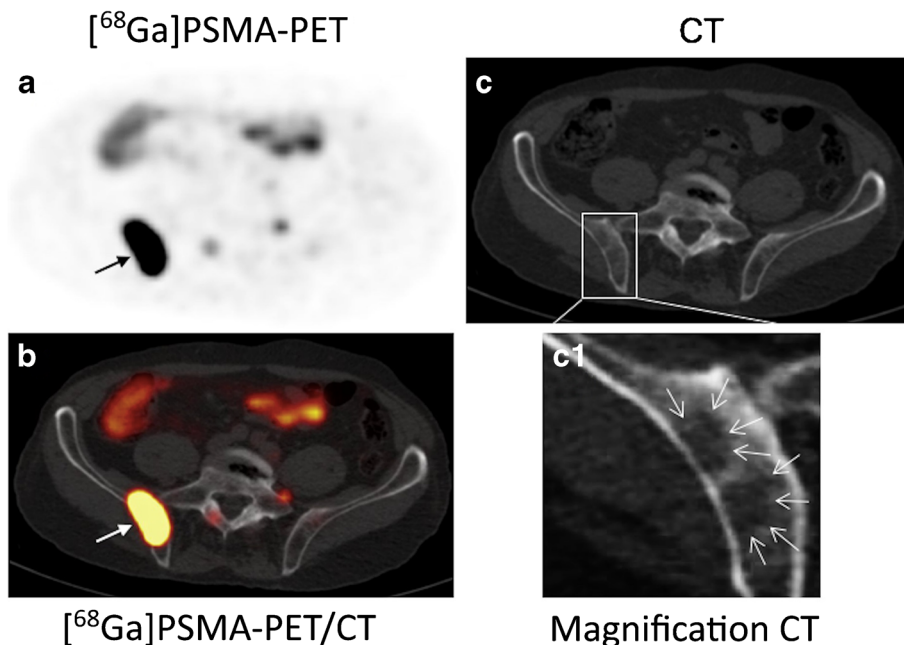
Example of an osteolytic bone metastasis in the right Os ilium with a strong $[^{68}\text{Ga}]\text{PSMA-HBED-CC}$ uptake. Example of a patient with a focal osteolytic metastasis (*thick arrow*) in the dorsal part of the right Os ilium. a, b In the $[^{68}\text{Ga}]\text{PSMA PET}$ image, an area with a strong $[^{68}\text{Ga}]\text{PSMA}$ uptake is visualized. The SUV_{max} of the lesion was 61.9, and the HU_{mean} was 87.8. c The corresponding CT image shows a corresponding diffuse osteolytic lesion in the right part of the right Os ilium (magnification c1, *thin arrows*).
